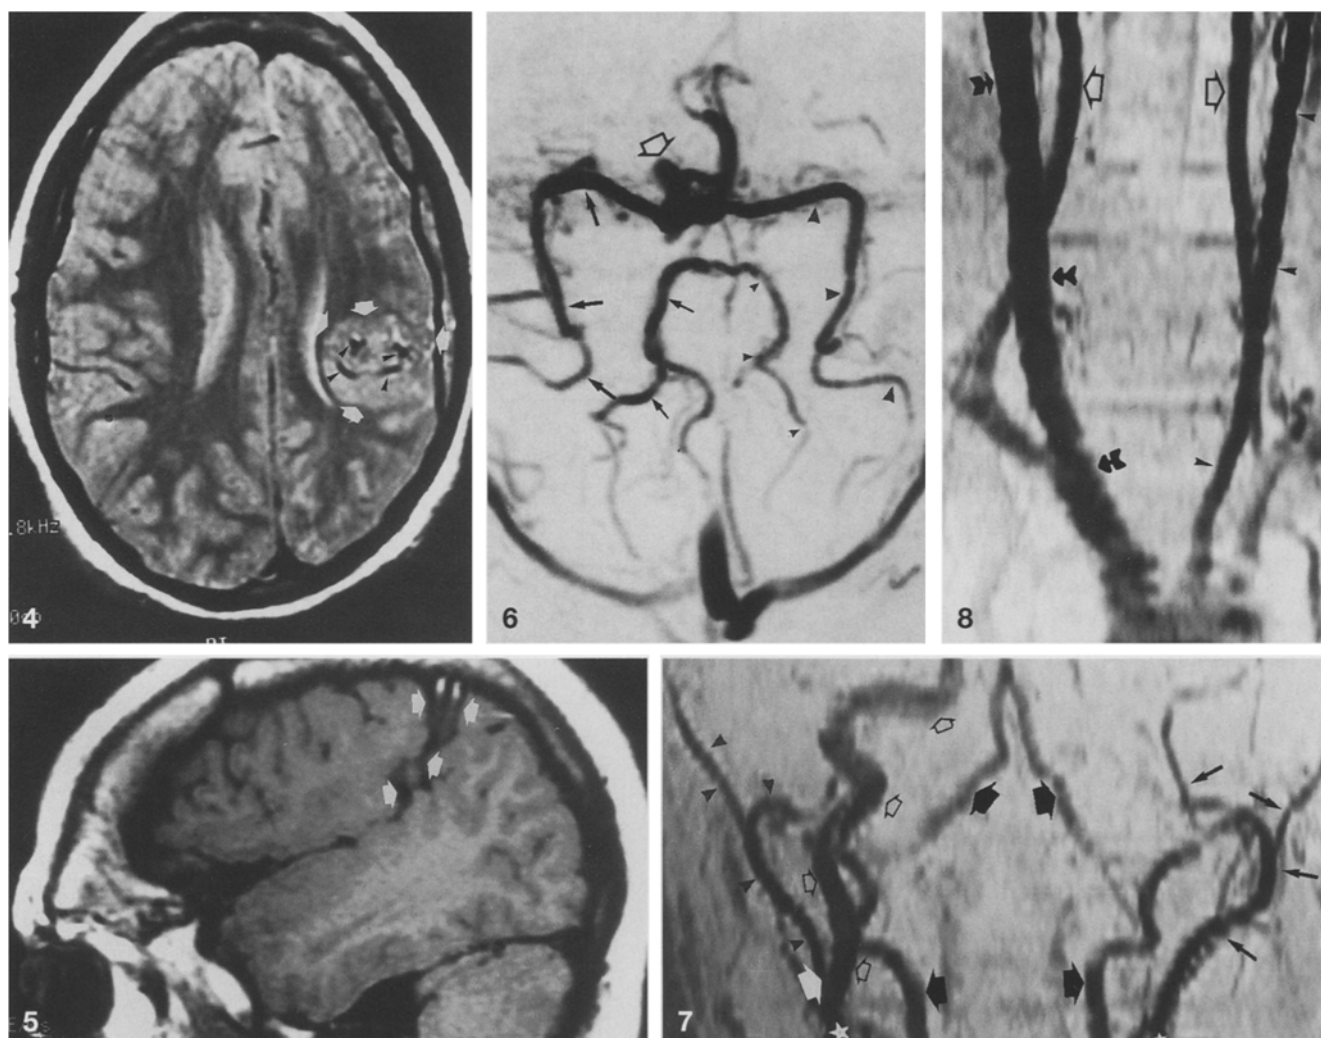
Axial T2-weighted (200/100) image shows a left hemisphere mass (*arrows*). Several large vessels (*arrowheads*) run within the infoldings of an abnormal grey matter mass. The left hemisphere is abnormally small
